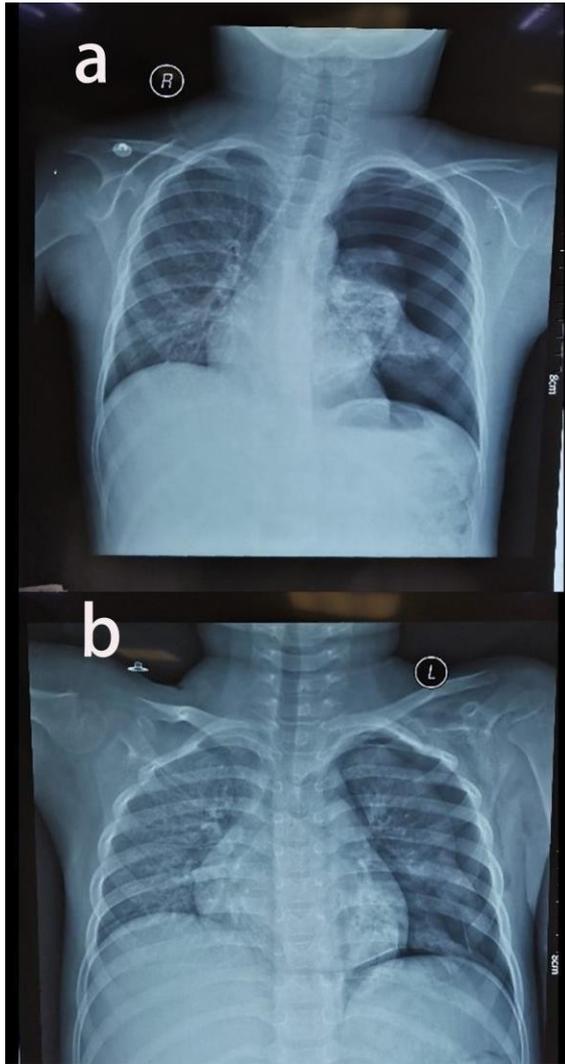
Chest radiograph images showing first pneumothorax with 80% pulmonary compression (a), and Left pneumothorax with 60% pulmonary compression (b).
